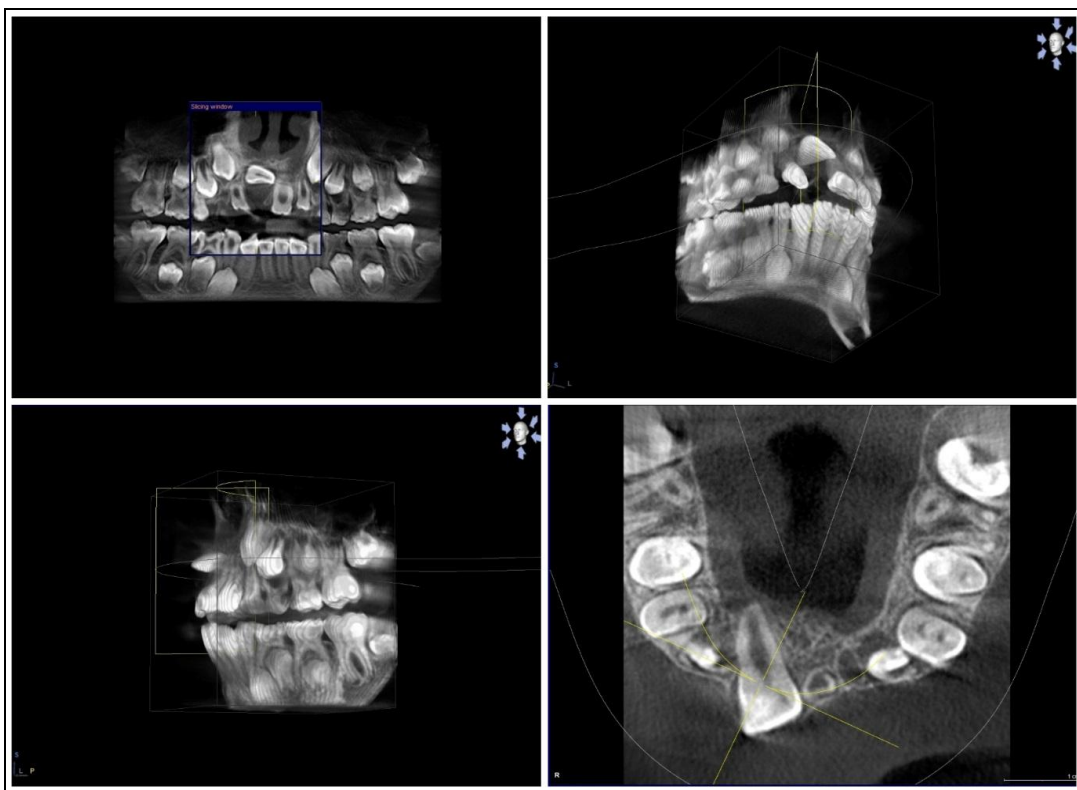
Pretreatment CBCT image of a child with the impacted maxillary right central incisor in different positions of the impacted tooth
